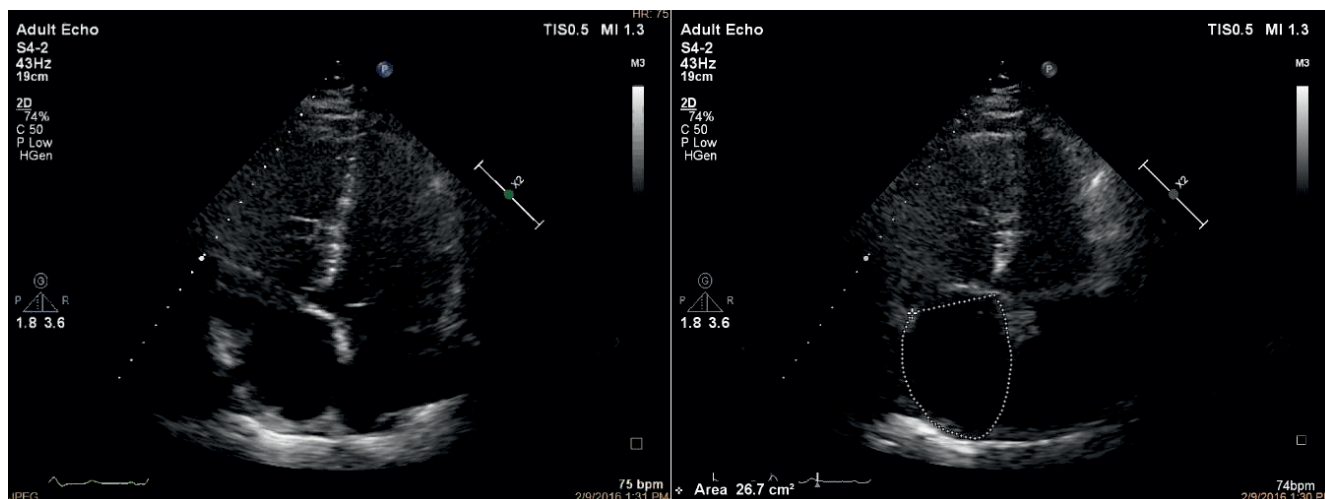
Transthoracic echocardiography, apical view, 2D, dilated RV, RA.
